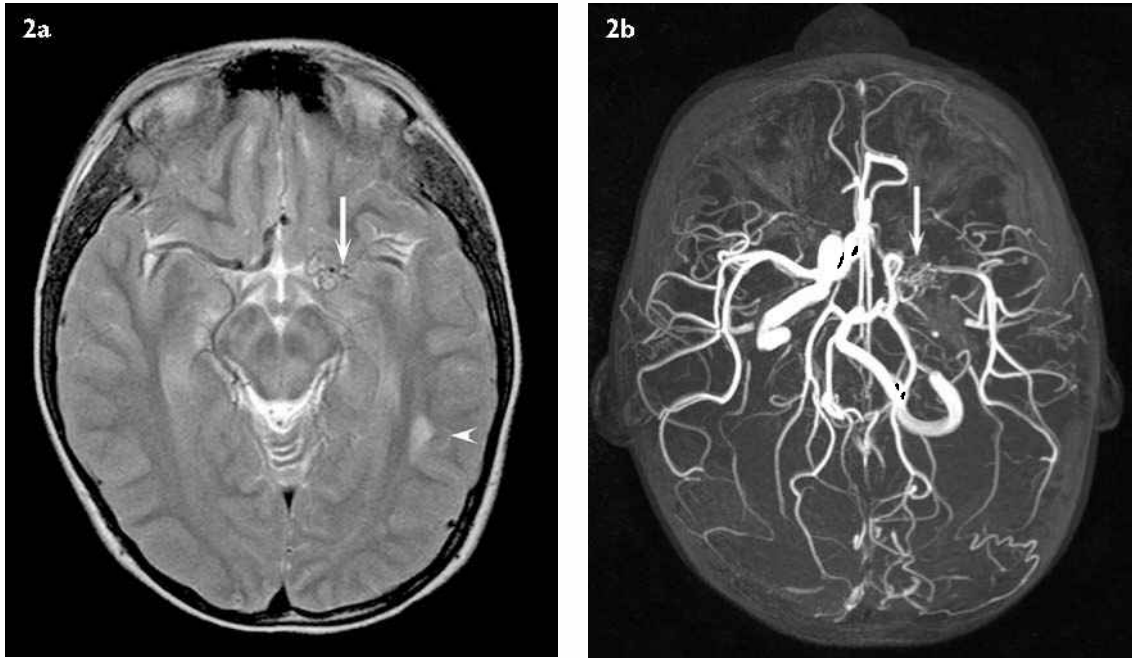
MR images taken four years later. (a) Axial T2-weighted MR image shows multiple serpiginous basal flow voids (arrow) consistent with collateral arteries from unilateral MMS and an ipsilateral hyperintense lesion in the temporal lobe white matter (arrowhead); (b) Maximum intensity projection MR angiography confirms occlusion of the terminal left ICA and severe stenosis of the proximal middle cerebral artery with multiple basal collateral arteries (arrow).
